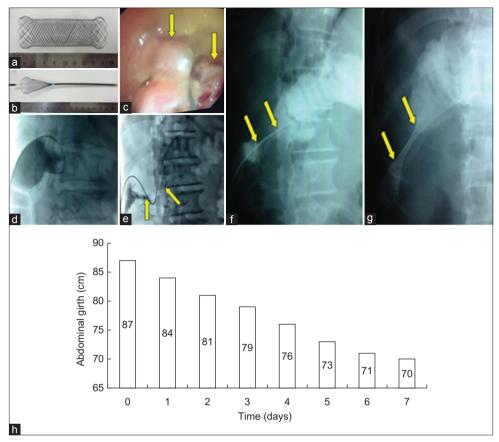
Super-flexible through-the-scope self-expandable metallic stent (a). Stent conveyor (b). Colonoscopy showing lumen occlusion with mass at hepatic flexure (yellow arrows; c). Digestive tract radiography confirmed the extent and length of the diseased colon (yellow arrows; d-f). Through-the-scope self-expanding metallic colorectal stent (26 mm \times 80 mm) was delivered and released at the occlusive (yellow arrows; g). Abdominal girth after super-flexible self-expanding metallic stent placement (h).
